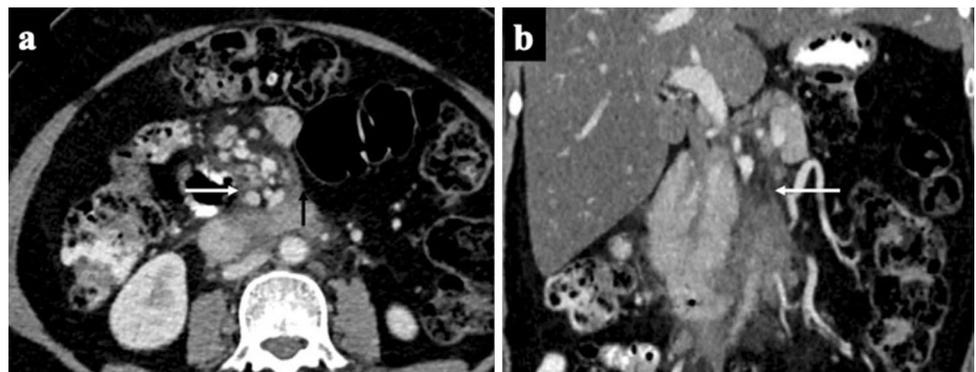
Malignant mesenteric root GIST in a 40-year-old male. a Axial CT image showing heterogeneously enhancing mass lesion (white arrow) in the mesenteric root, encasing the superior mesenteric artery (black arrow). b Axial CT image showing heterogeneously enhancing mass lesion in the liver suggestive of metastasis (Black asterisk)
